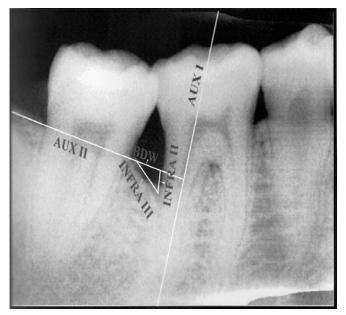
Radiographic images during assessment of intrabony component.
